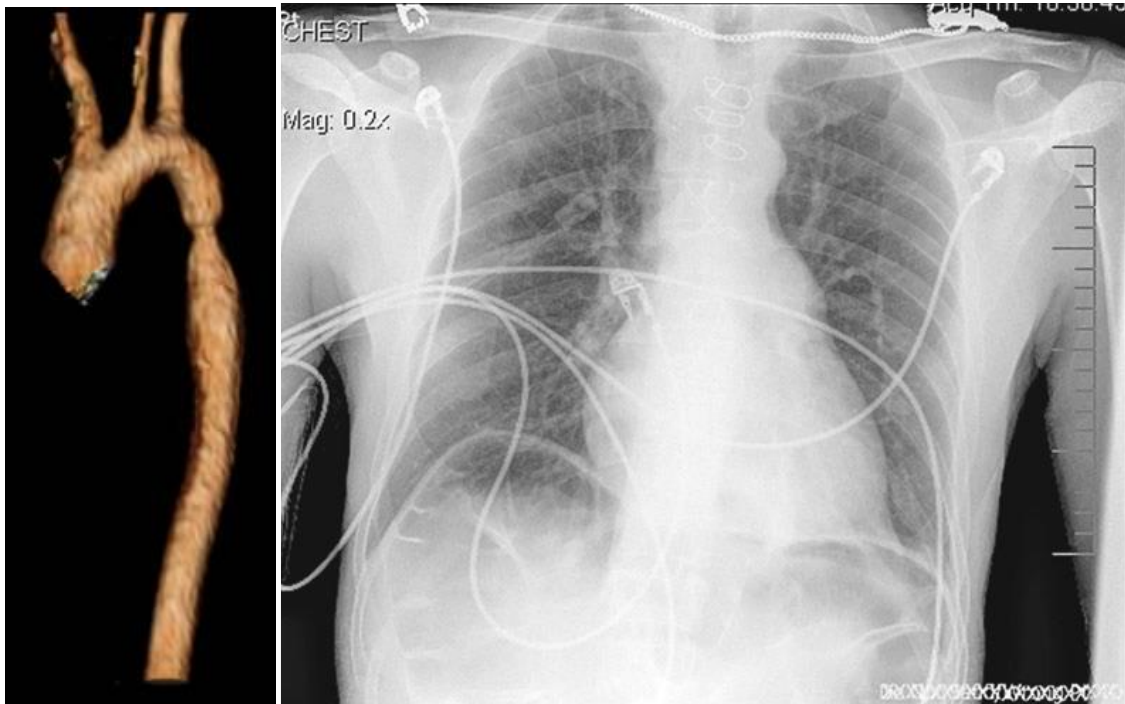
Left: Discrete coarctation anatomy by CT angiography, sagittal section (*Curr Cardiol Rep* 2015). Right: CXR demonstrating aortic indentation at the coarctation site (“3 sign”) (*Cur Cardiol Rep* 2015)
